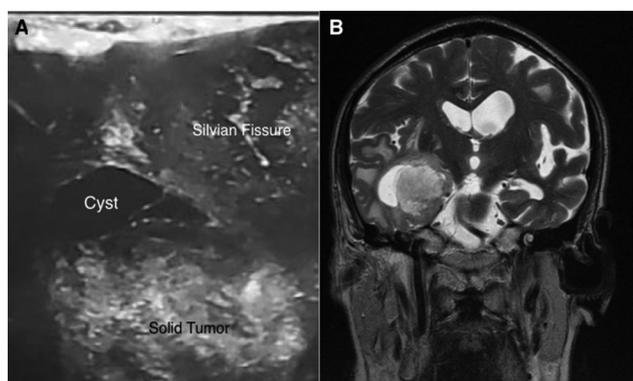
Intraoperative US image (A) and preoperative MRI (B). The lesion had a cystic portion that in US is viewed as hypoechoic; the solid part of the tumor is hyperechoic with some calcified portions that can be identified because of its brighter color on the screen. MRI, magnetic resonance imaging; US, ultrasound.
